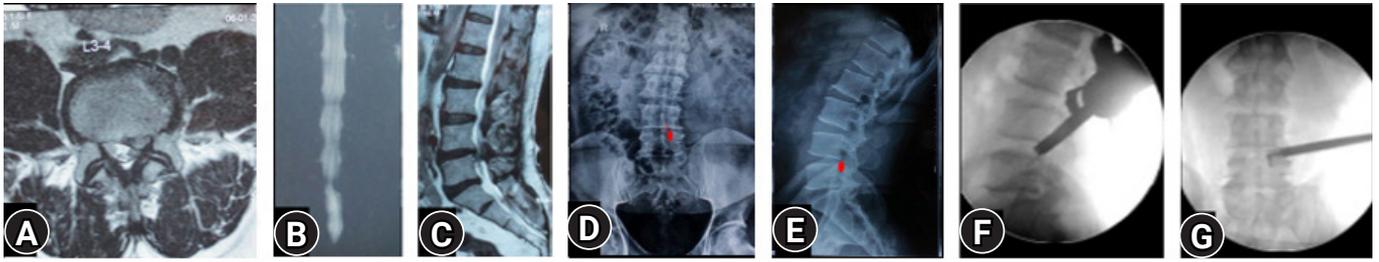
(A–C) MRI of L3–4 para-central location low migrated LDH on left side. (D, E) Superimposed traced fragment (Red) in an antero-posterior and lateral radiograph. (F, G) The position of the endoscope tip and the articulated hook checked on C-arm for target area location assessment. End point decompression (EPD) is confirmed after fragment retrieval and inferred with target area location and re-affirmed with a post-operative MRI later.
